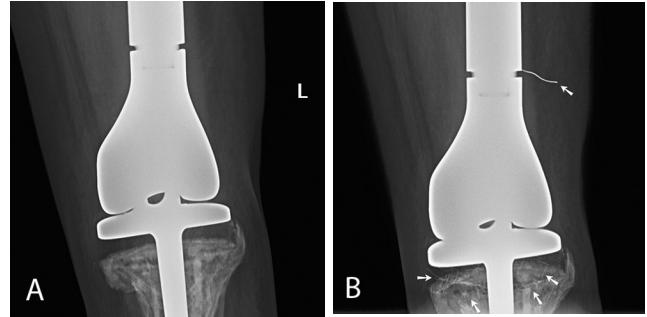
Frontal radiographs of the left distal femur and knee A) immediately post surgery and B) 6 months post surgery. The immediate image is free of any unanticipated radioopaque foreign bodies. The 6-month image demonstrates multiple new metallic wire fragments within the knee joint and a dominant wire fragment projecting laterally into the distal thigh (arrows).
